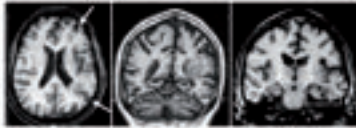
Hippocampal. Coronal T2-weighted images showing various patterns of hippocampal abnormalities. Note that the cortex above the lesion is abnormal and probably undergoes some of the changes seen in FCD. Axial T2-weighted images showing that the hippocampal malformation is ipsilateral to the cortical malformation. Coronal T2-weighted images showing that the hippocampal malformation is ipsilateral to the cortical malformation.
